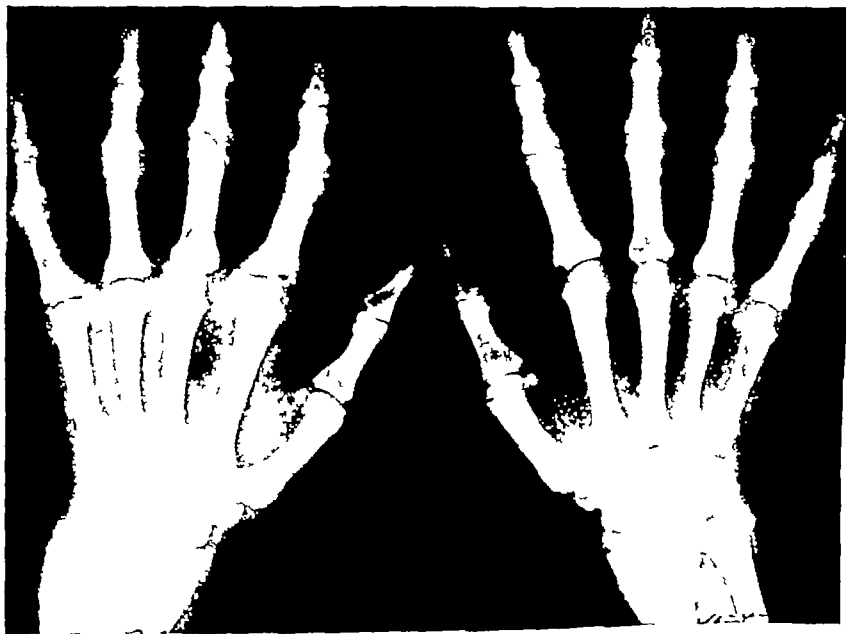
Chronic rheumatoid arthritis of ten years' duration in a fifty two year-old female. The disease began in the proximal interphalangeal joints and later spread to the wrists elbows shoulders ankles and knees. Roentgenograms of the hands and wrists show many stages of rheumatoid arthritis in the different joints. Some of the proximal interphalangeal joints are beginning to ankylose. The terminal joints are essentially normal.
